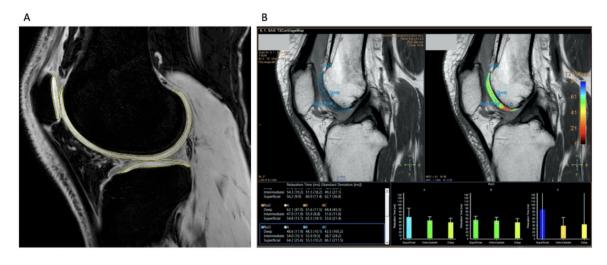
Quantitative MRI analysis. (A) Single sagittal T1-weighted fat saturated image of a participant's knee with outline used to calculate segmental cartilage volume. (B) Single sagittal T2 mapping image of a participant's knee showing calculated segmental cartilage T2-value assessment.
